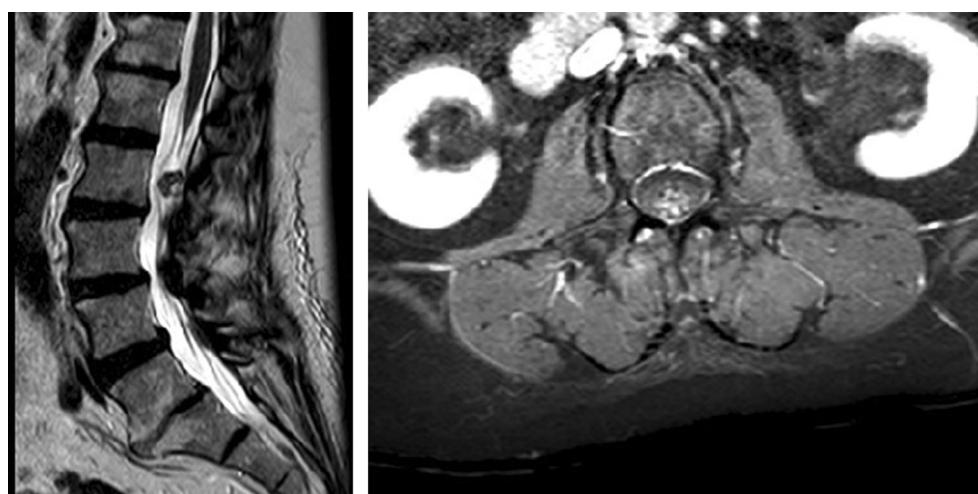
Magnetic resonance imaging (MRI) of the lower spine showing (sagittal plane T2-weighted section on the *left*, axial contrast enhanced T1 section on the *right*) a round, intraspinal, intradural mass in the dorsal part of the spinal canal at the level L2 without any contrast enhancement
